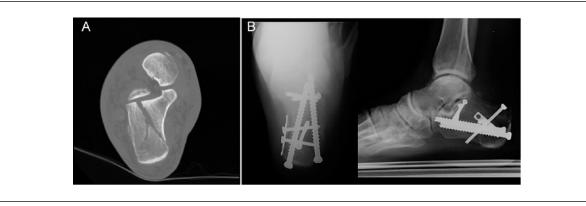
(A) Preoperative axial CT scan. (B) Postoperative Harris heel and lateral view radiograph. Note the anatomic alignment of the medial wall and reduction of the tuberosity out of varus.
